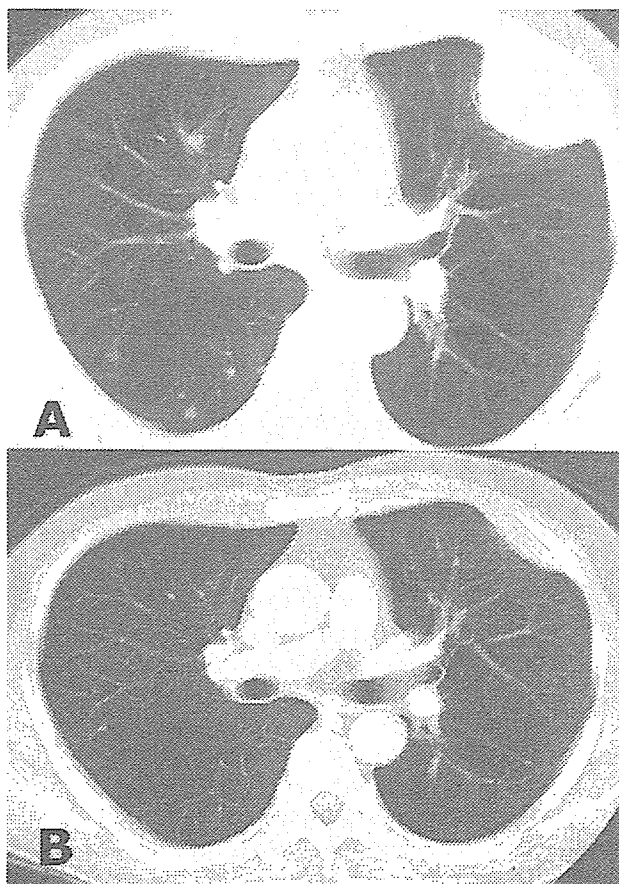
Computed tomography of the chest before (A) and 722 days after (B) transplantation in patient 6. Pleural and pulmonary metastases were reduced after transplant. The patient achieved partial remission.
